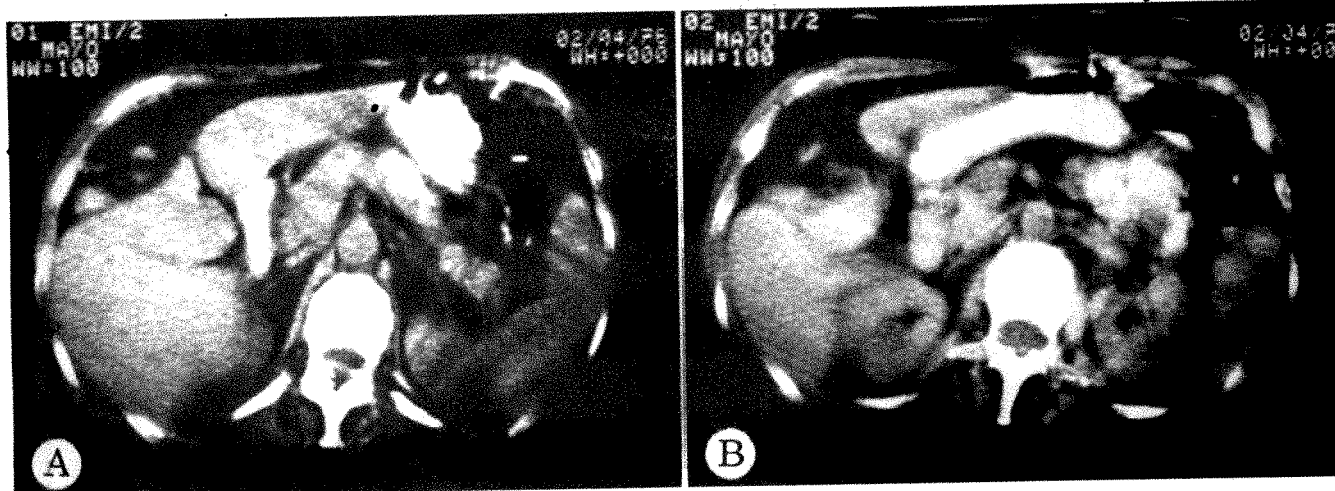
CT scans after ingestion of dilute water-soluble contrast material in 55-year-old woman with bilateral thrombophlebitis examined for possible malignancy. *A*, Contrast material in midportion of stomach and second portion of duodenum clearly separates duodenum from head of pancreas. *B*, Contrast material in body and antrum of stomach clearly separates posterior portion of stomach from anterior portion of normal head of pancreas.
